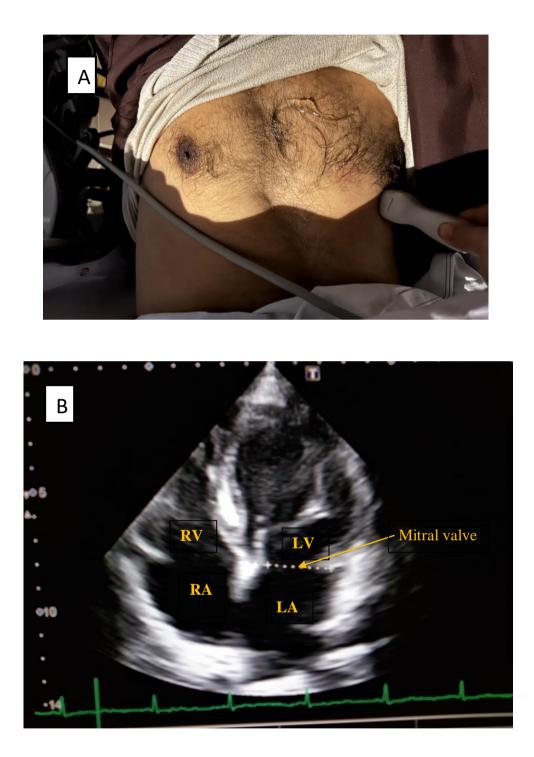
(A) Transducer position for 4-chamber view. (B) Echocardiographic image for a 4-chamber view from the current study conducted at NICVD, Karachi. RV=right ventricle; RA=right atrium; LV=left ventricle; LA=left atrium.
